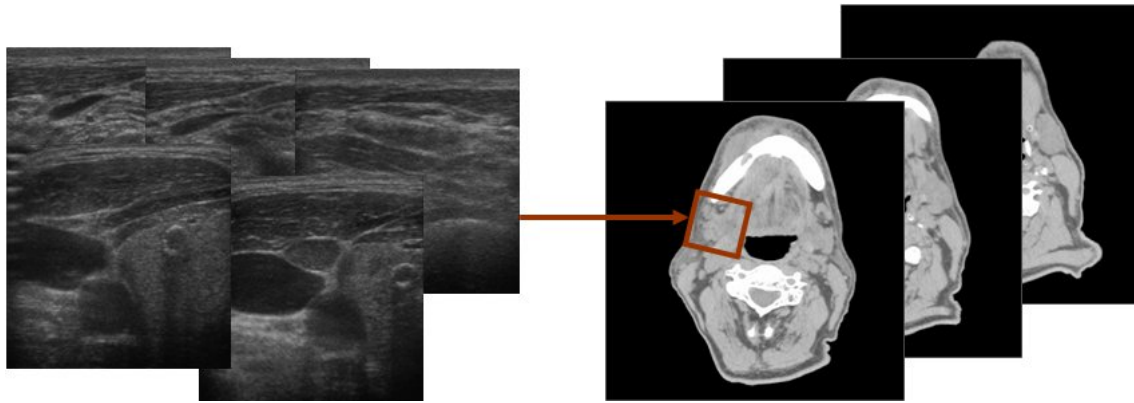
Ultrasound images of neck lymph nodes (left) and their relation to the CT slices (right) used for radiotherapeutic treatment planning.
